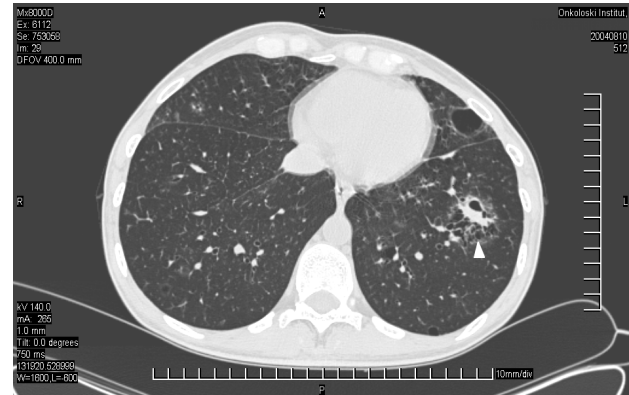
High-resolution computed tomography in August 2004 at the same level as Figure 2. The most of parenchymal consolidation was replaced by small thin walled cysts.
